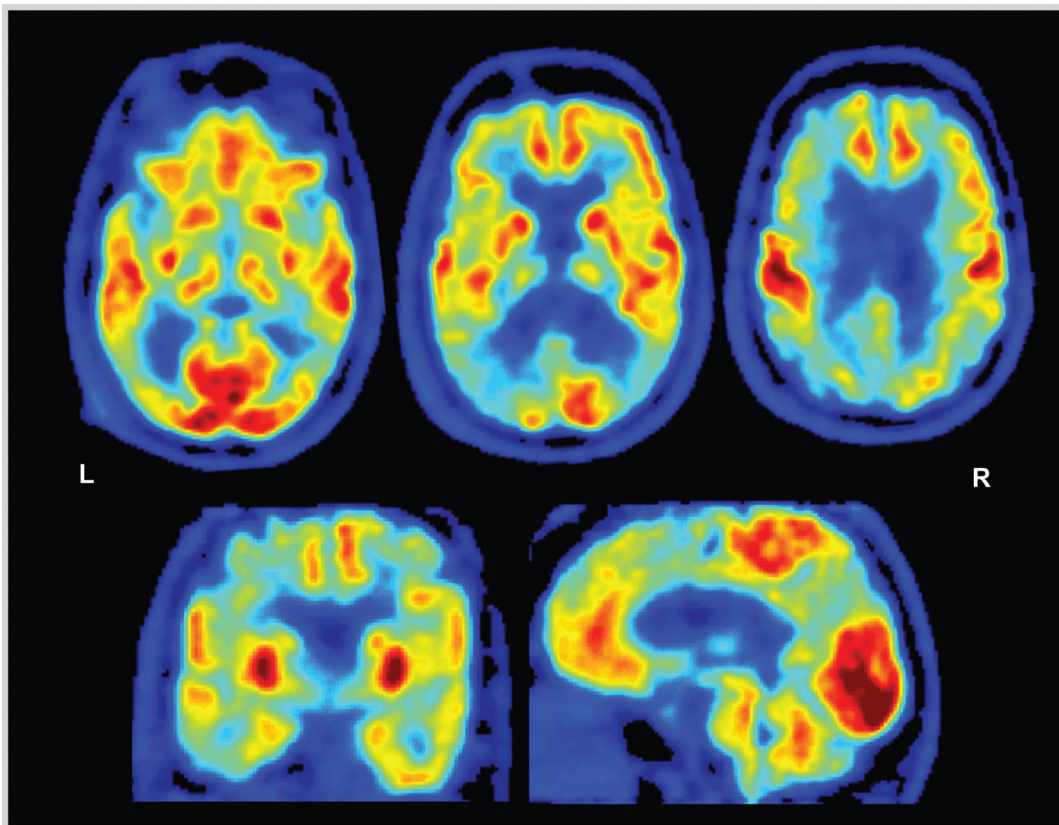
Fluorodeoxyglucose positron emission tomography (FDG-PET) of the patient in Case 4-2. Images displayed in the National Institutes of Health color scale in neurologic orientation. Hypometabolism is noted in bilateral temporoparietal and dorsal prefrontal cortex. Temporoparietal hypometabolism is the FDG pattern associated with Alzheimer disease, while additional involvement of the prefrontal cortex may explain the prominent executive dysfunction experienced by the patient.
